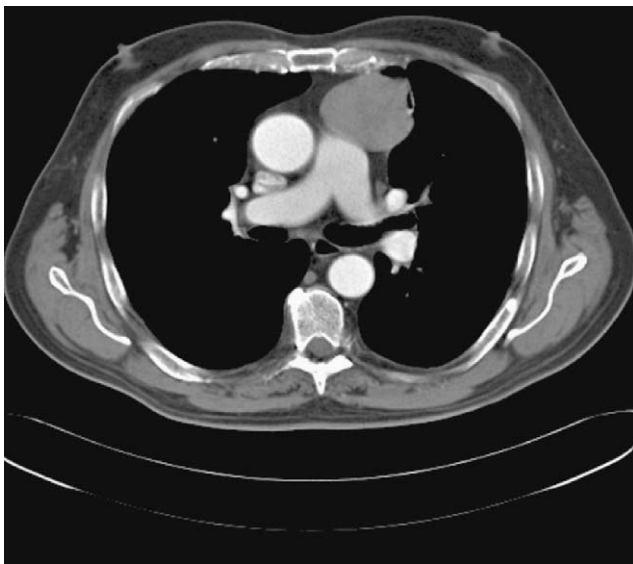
CT shows a large mass in the anterior mediastinum.
